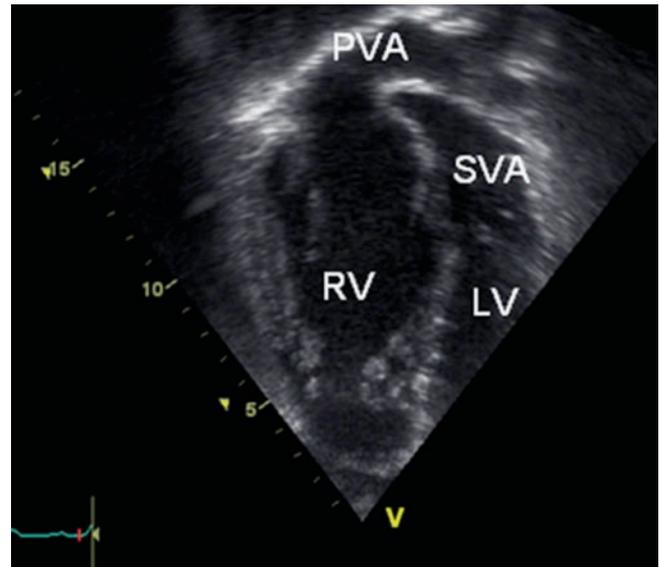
Apical 4-chamber view of patient after the Senning operation. Notice the baffle in the atrium. The pulmonary venous atrium (PVA) is directing the pulmonary venous blood to the right ventricle. The systemic venous blood is directed through the systemic venous atrium (SVA) to the left ventricle. The RV is the systemic ventricle after this operation
